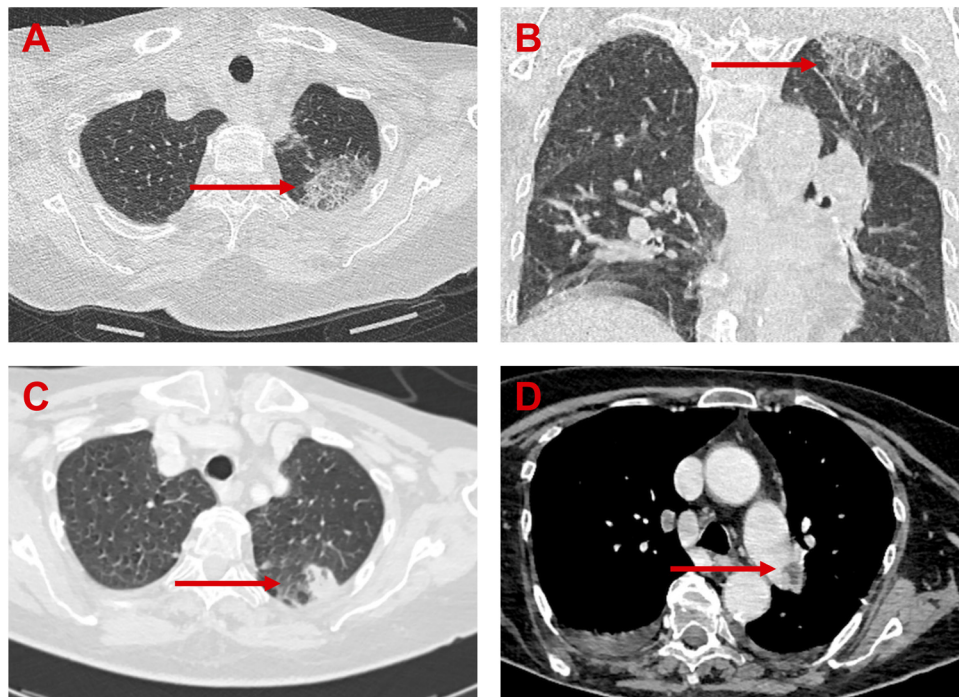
(A) Initial CT-Scan; axial lung window: red arrow indicates peripheral ground-glass opacity/ visible intralobular lines (“crazy-paving”) (B) Initial CT- Scan; coronal lung window: red arrow indicates peripheral ground-glass opacity/ visible intralobular lines (“crazy-paving”). (C) Follow up CT-Scan; axial lung window: red arrow indicates pleural-based opacification- consistent with a post-infarction pneumonia (D) Follow up CT-Scan; axial mediastinal window: red arrow indicates pulmonary embolism (PE).
